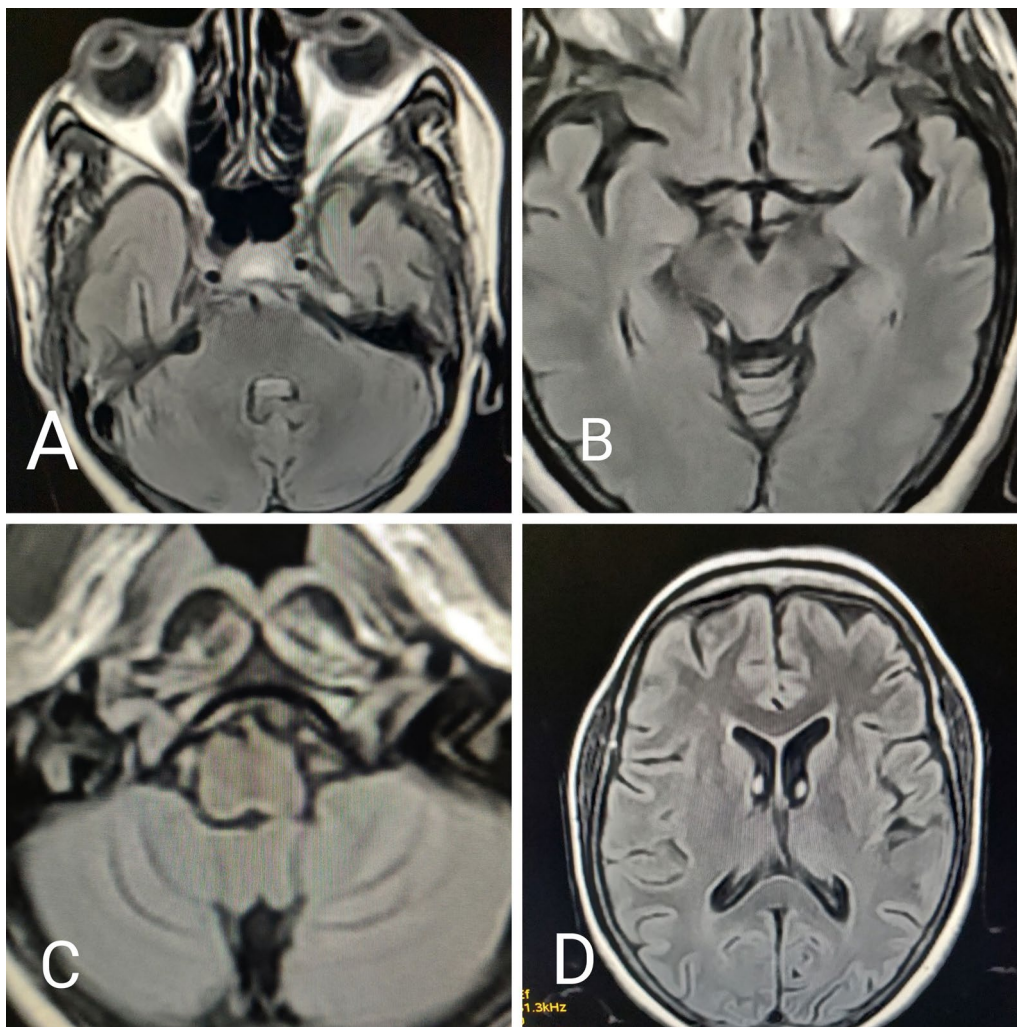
MRI brain shows contrast enhancing lesions in A left middle cerebellar peduncle, B left temporal juxtacortical white matter and C shows leptomeningeal enhancement. D Susceptibility weighted imaging done after 12 wks shows microhemorrhage in the left temporal juxtacortical white matter
